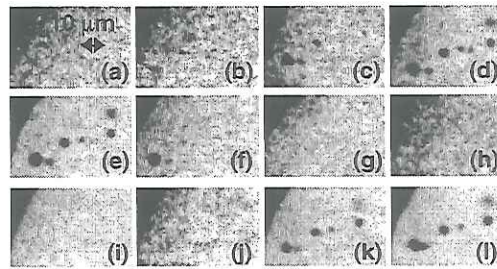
High-speed photographs (8 frames/cycle) of cavitation bubbles produced by 250-kHz ultrasound.
